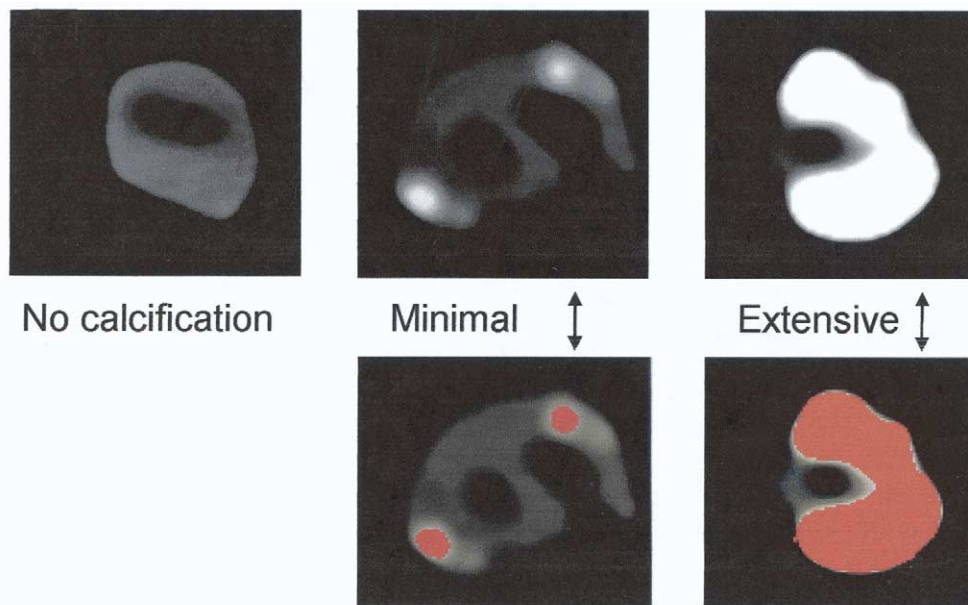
Spiral computed tomography cross-section images of plaques with variable degrees of calcification. Calcification area was measured with computer-assisted morphometry with color density scale analysis (calcified regions in the 0-100 range vs noncalcified regions in the 100-250 range).
